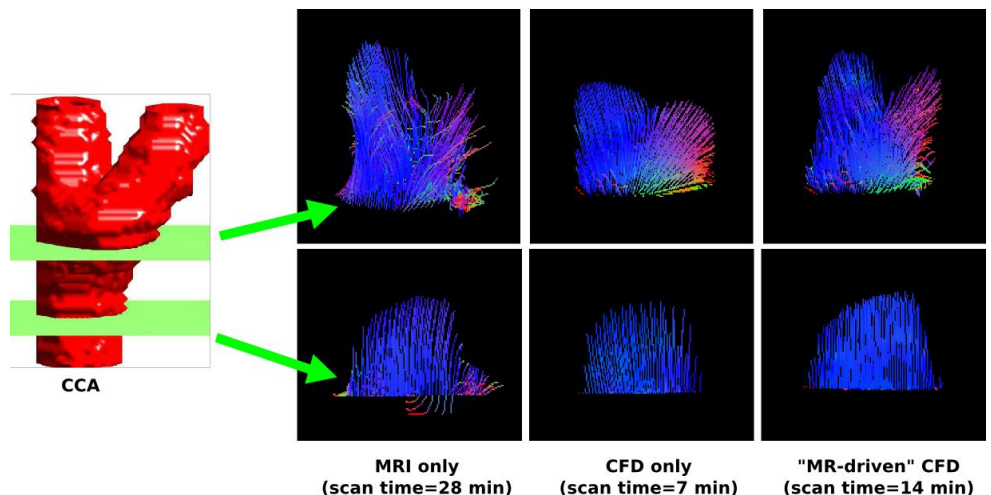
Pathline visualization of blood flow in the carotid bifurcation (top) and the common carotid artery (bottom), using flow fields at mid-systole obtained with 4-point phase-contrast MRI (left), CFD only (middle), and the proposed MR-driven CFD approach (right). Each line shows the path of a massless particle during the course of 60 ms (top) or 20 ms (bottom), under the assumption of a constant velocity field. Pathlines are RGB color-coded according to the local velocity direction (vertical=blue; in-plane=red and green). These flow fields were obtained from 4 (left), 1 (middle), or 2 MRI scans, corresponding to total scan times of 28, 7, and 14 min, respectively.
